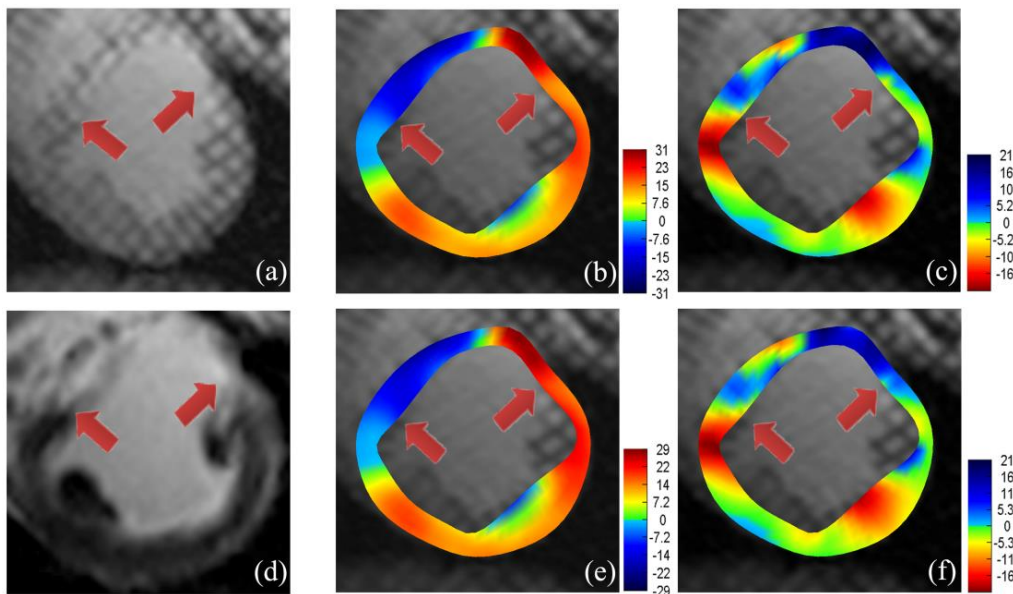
(Dys)functional regions detection using different methodologies. (a) t-MRI at end-systole, (d) DE-MRI, (b/e) radian strain map and (c/f) circumferential strain map using the sequential 2D (top) and the proposed sequential 2D+t (bottom). The arrows represent the borders of the dysfunctional region.
